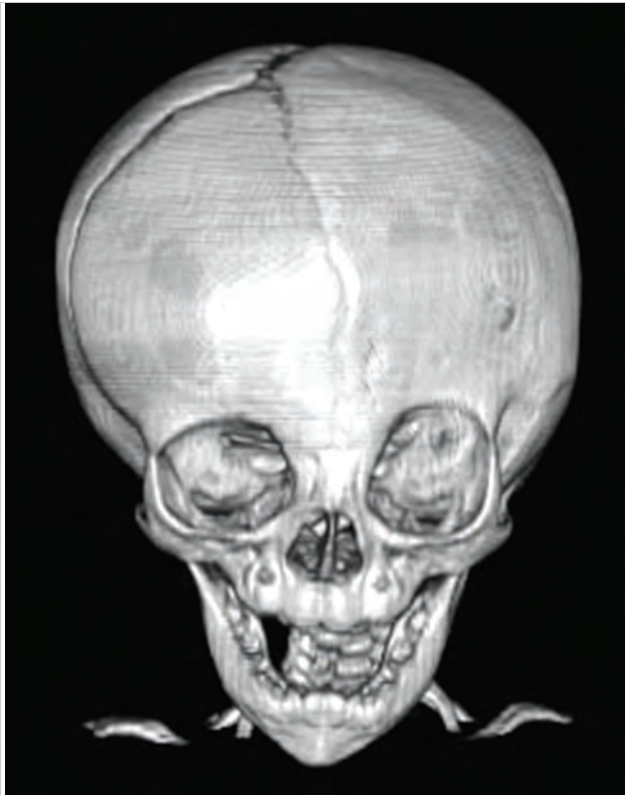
CT image demonstrating unilateral coronal synostosis.
